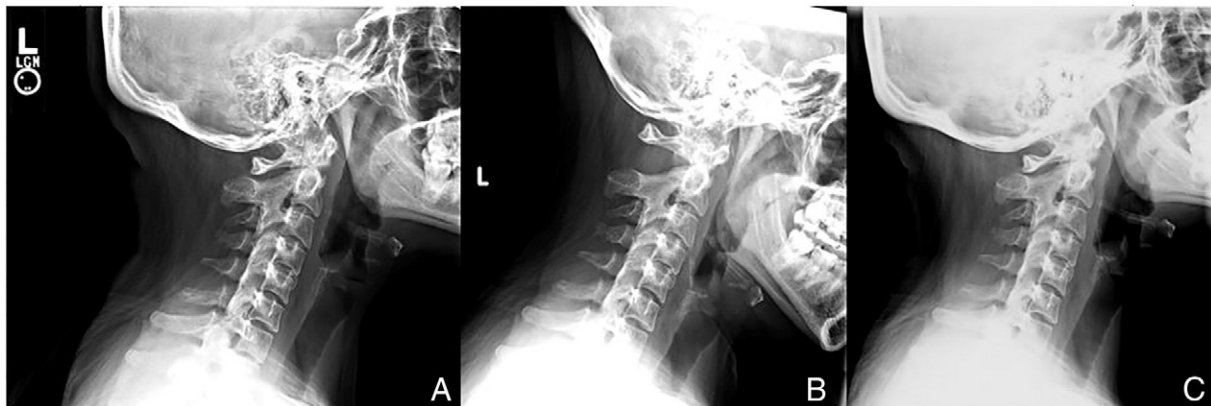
(A) Radiographic examination of the cervical spine in case 1 revealed indistinct cortical margins and osteopenia of the articular pillars. The apophyseal joints were diminished, predominately in the mid to lower cervical segments, whereas the intervertebral disk spaces were well maintained. (B) Flexion and (C) extension revealed restricted sagittal range of motion of the cervical spine.
